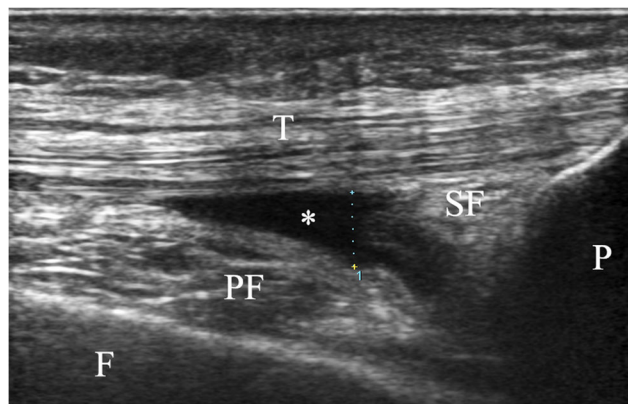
Ultrasound image, longitudinal view of the suprapatellar pouch observed as a hypoechoic structure and measuring the maximum anteroposterior diameter (P, patella; F, femur; T, quadriceps tendons; SF, suprapatellar fat-pad; PF, prefemoral fat-pad; asterisks, suprapatellar pouch)
